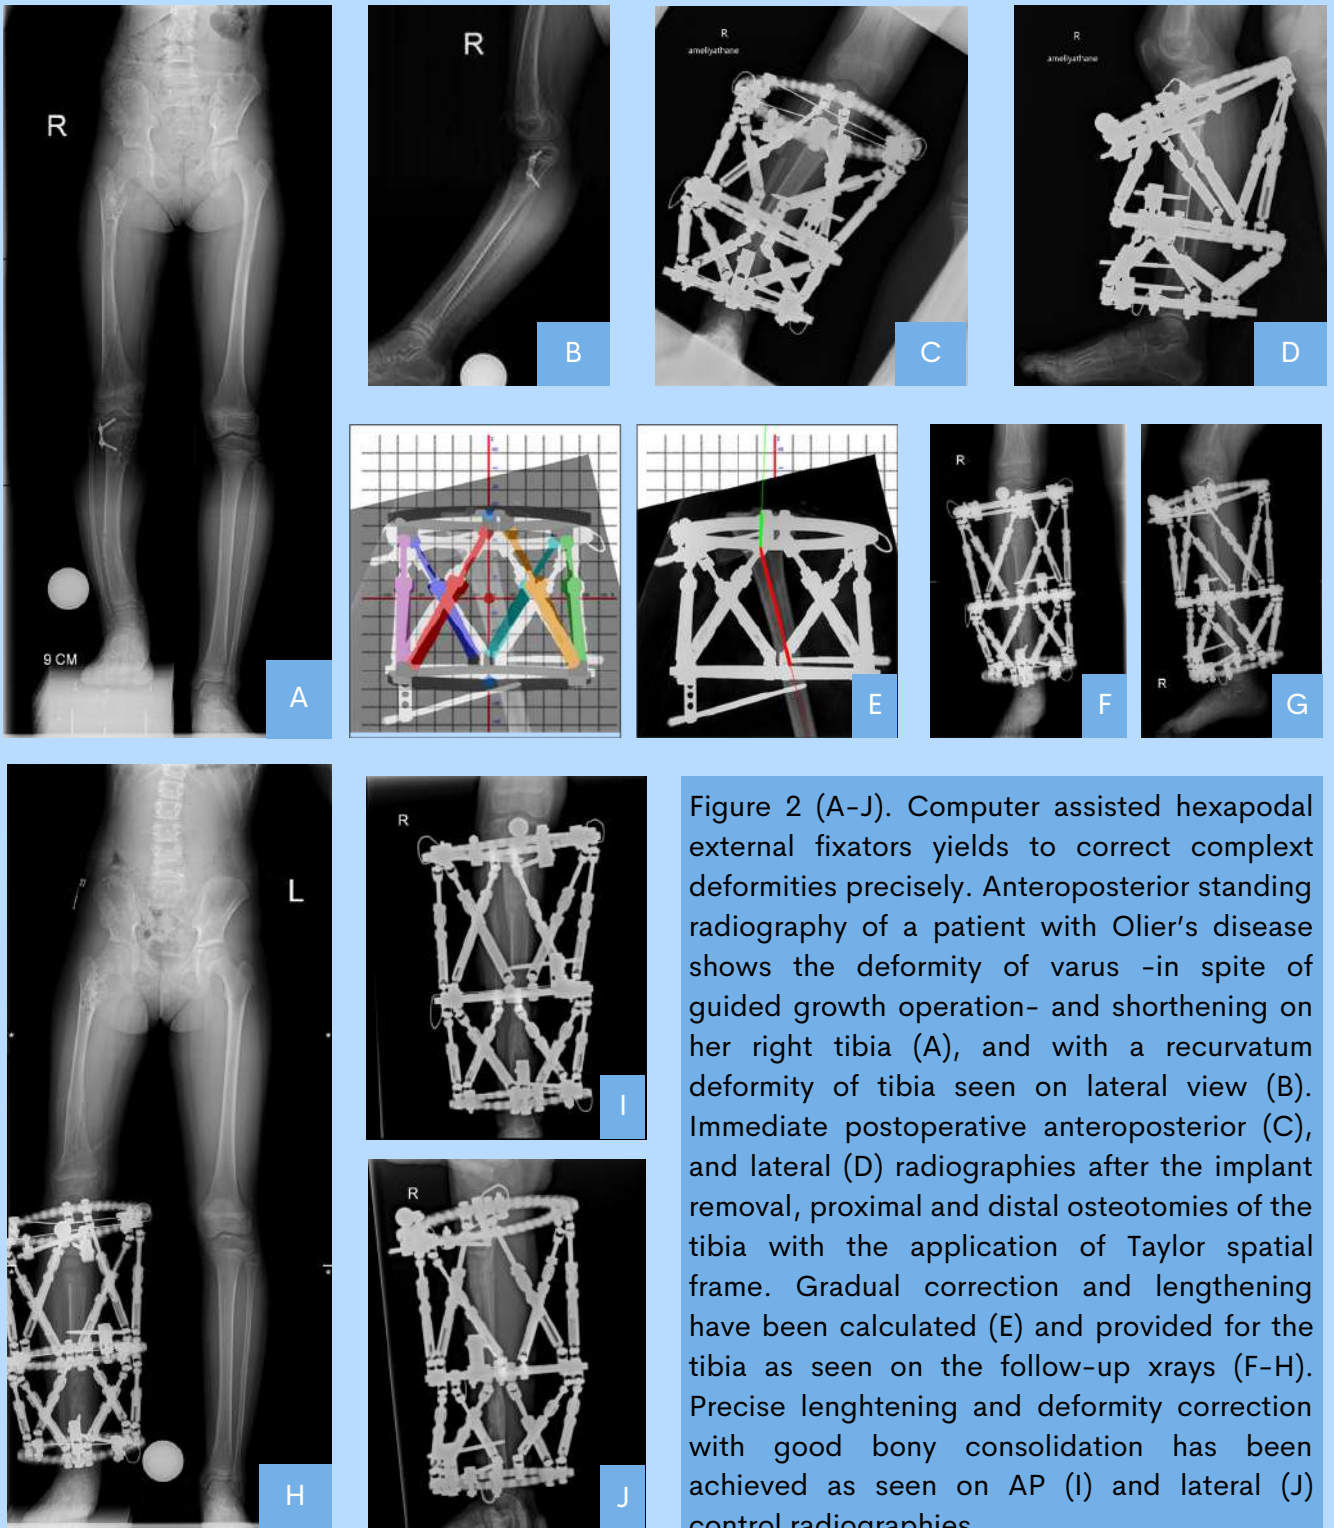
(A-J). Computer assisted hexapodal external fixators yields to correct complex deformities precisely. Anteroposterior standing radiography of a patient with Olier's disease shows the deformity of varus -in spite of guided growth operation- and shortening on her right tibia (A), and with a recurvatum deformity of tibia seen on lateral view (B). Immediate postoperative anteroposterior (C), and lateral (D) radiographies after the implant removal, proximal and distal osteotomies of the tibia with the application of Taylor spatial frame. Gradual correction and lengthening have been calculated (E) and provided for the tibia as seen on the follow-up xrays (F-H). Precise lengthening and deformity correction with good bony consolidation has been achieved as seen on AP (I) and lateral (J) control radiographies.
